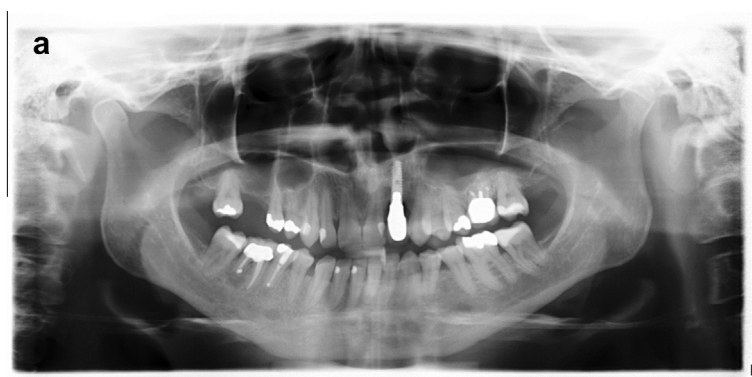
Images of orthopantomograms performed on 22nd November 2011 (a) and 13th June 2012 (b). (a) The first examination revealed apical radiolucencies of the lower right first molar and the lower right second premolar. (b) The second orthopantomogram showed slightly sclerotic extraction sockets in the right mandible.
